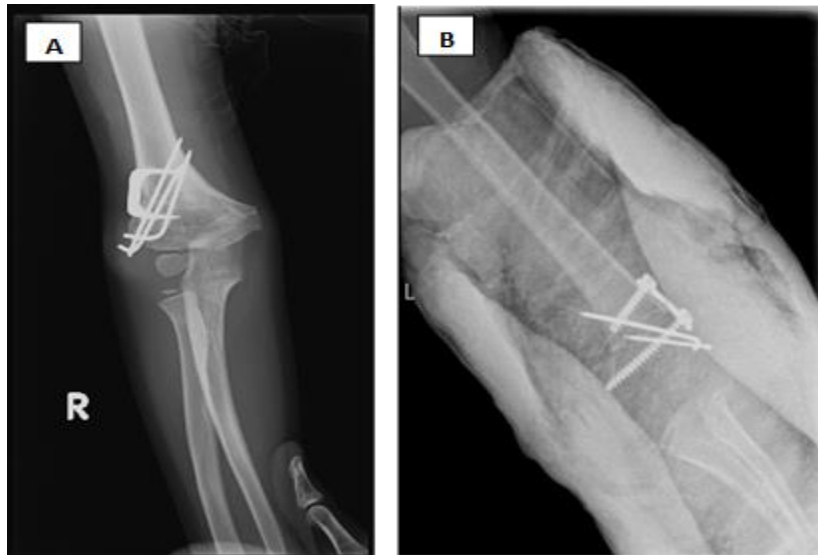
Anteroposterior radiograph of an elbow supracondylar osteotomy taken prior to hardware removal, fixed with an augmented construct using K-wires and a lateral Blount staple
